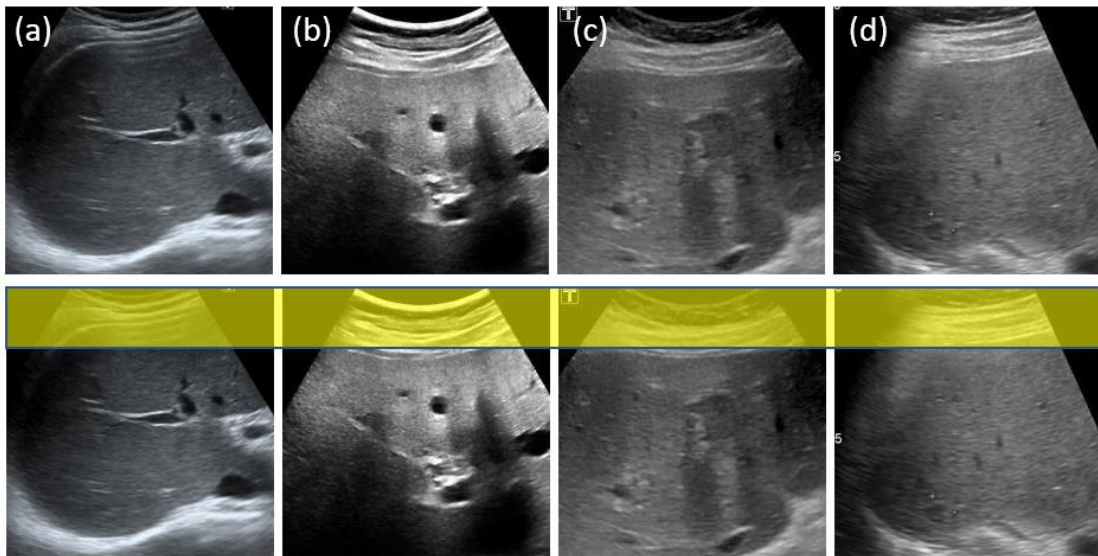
Top row: Liver ultrasound images - (a) Homogeneous liver, (b) Hepatic cyst, (c) Hepatocellular carcinoma (HCC), and (d) Hepatic hemangioma (HEM). Bottom row: Abdominal wall indicated by yellow box.
